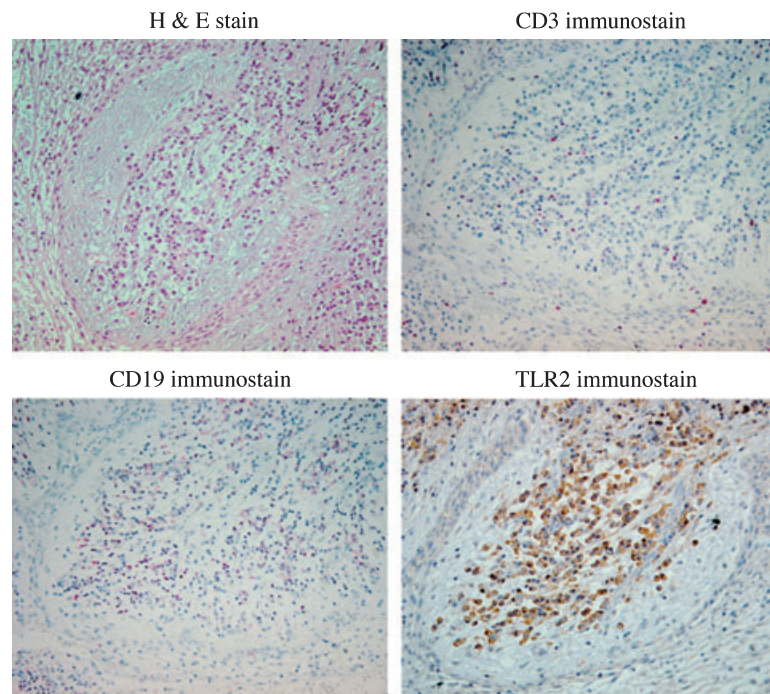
Serial sections from a periapical cyst demonstrating greater numbers of CD19⁺ B cells than CD3⁺ T cells associated with TLR2⁺ mononuclear cells (×200).
